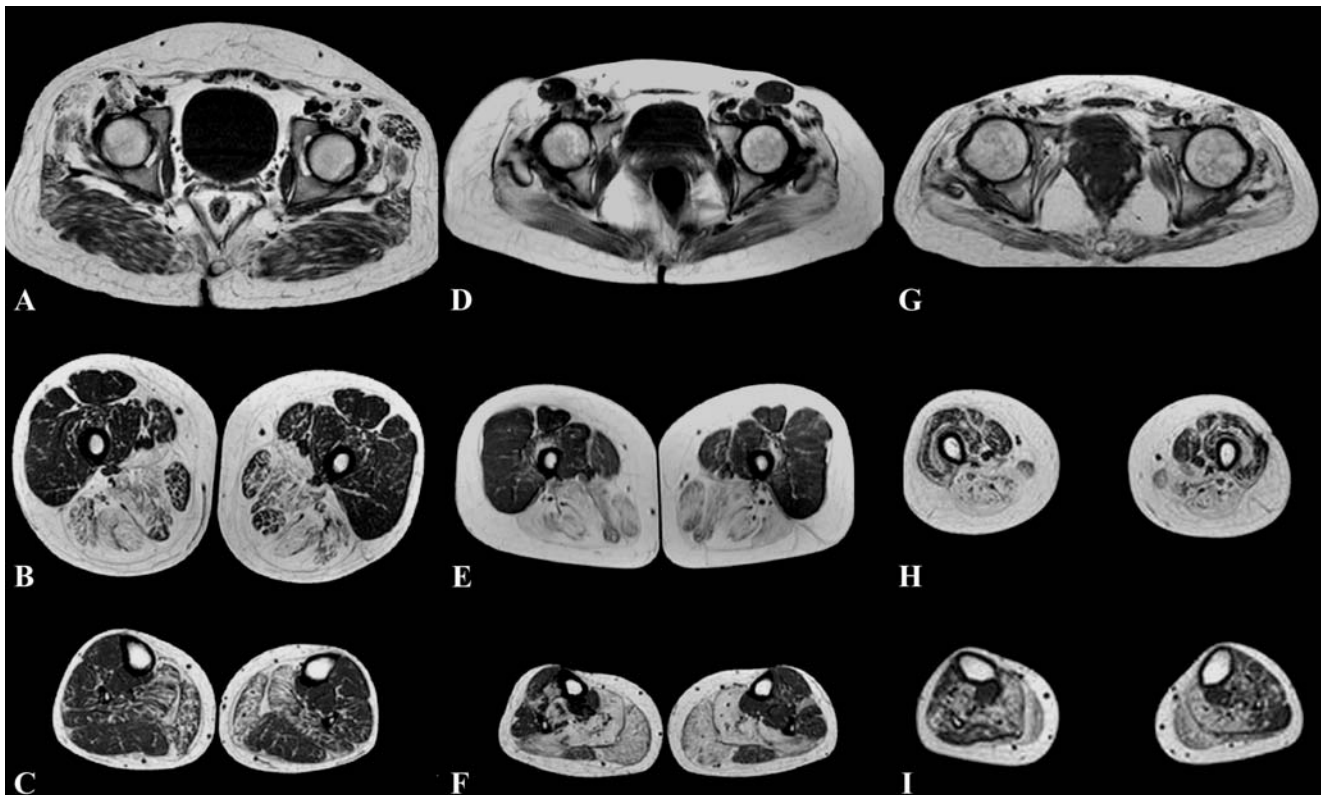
Muscle MRI of three patients with genetically confirmed primary calpainopathy (LGMD2A) with a mild (A, B, C), moderate (D, E, F) and severe (G, H, I) clinical phenotype. It is noteworthy that, at the pelvic level there is progressive atrophy of the gluteus maximus muscle (A, D, F), which is not seen in LGMD2I and LGMD2B. At the thigh level, similar to LGMD2I, the earliest and most severe changes are observed in the adductor and posterior compartment muscles, whereas in patients with a severe phenotype (G, H, I) additional changes are seen in the quadriceps muscle. In contrast to LGMD2I, vastus intermediolateralis and vastus medialis/rectus femoris muscle are involved at the same degree (H). In the lower legs, there is a characteristic pattern of relative homogeneous and selective involvement of the medial head of the gastrocnemius and the soleus muscle, which is not seen in other LGMDs
